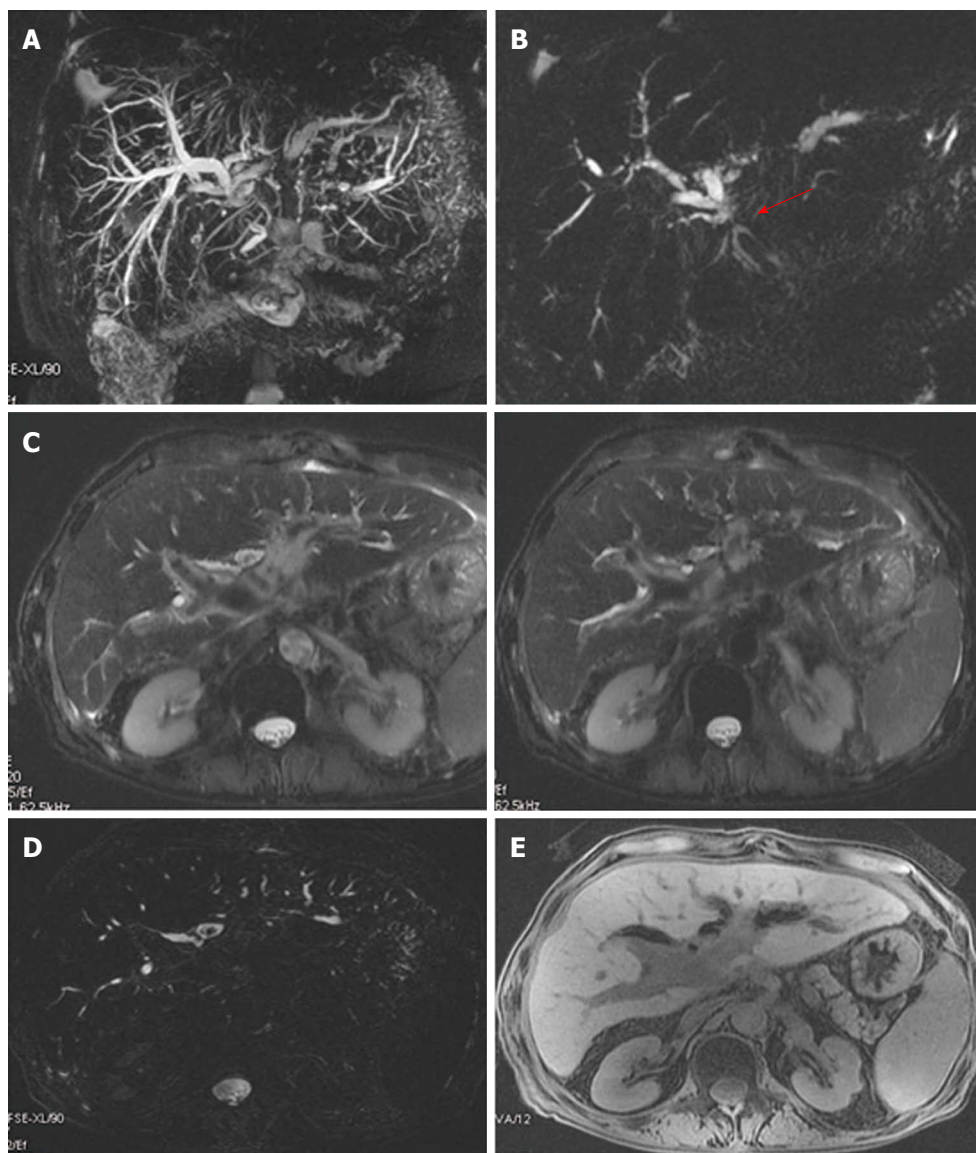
Anastomotic biliary stricture with lithiasis in a patient with hepatico-jejunostomy. A: Maximum intensity projection reconstruction of 3D thin-slab fast spin-echo T2-weighted images shows marked dilation of the biliary system with partial visualization of the left hepatic duct; B: Single-shot thick-slab magnetic resonance cholangiogram well depicts the stricture of the anastomotic site (red arrow); C, D: Axial single-shot T2-weighted images and axial 3D thin-slab fast spin-echo T2-weighted image demonstrate dilation of the pre-anastomotic biliary tract with the presence of pneumobilia, in particular at the level of left and common hepatic ducts with concomitant stones into the left one; E: Axial T1-weighted image better recognizes pneumobilia.
